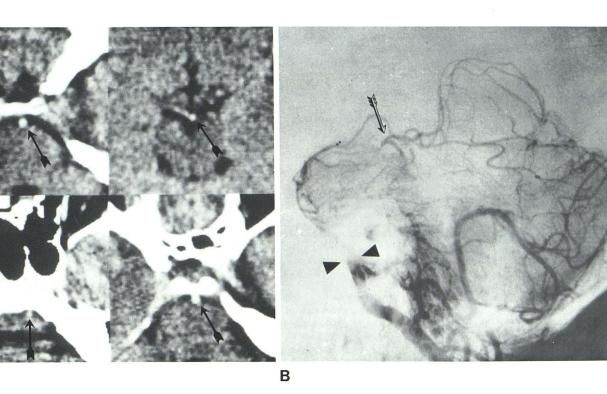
Case 4. Distal basilar artery occlusion. A, Plain CT scans. Attenuation values of basilar artery (*arrows*): *upper right*, 60 H; *upper left*, 65 H; *lower right*, 67 H; *lower left*, 43 H. First three readings represent occlusion of distal part of artery. Reading in scan at lower left represents normal
